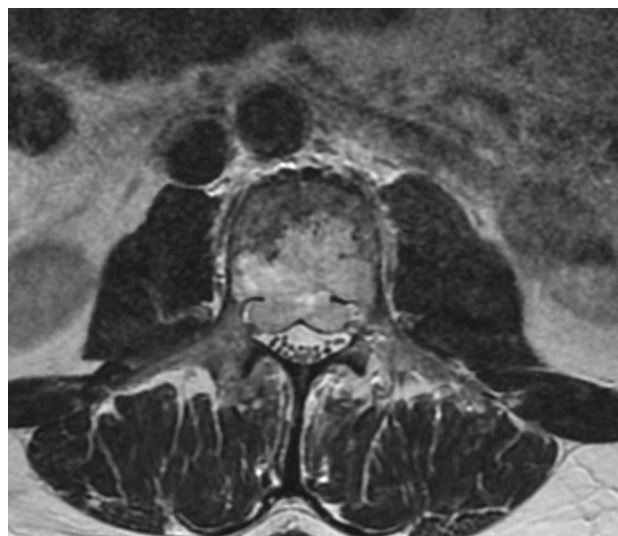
MRI of the chordoma of L3. Sectors involved are 9–4 (body and both pedicles). Layers B, C, and D. The tumor is contained inside the vertebral body but involving the epidural space (layer D)
